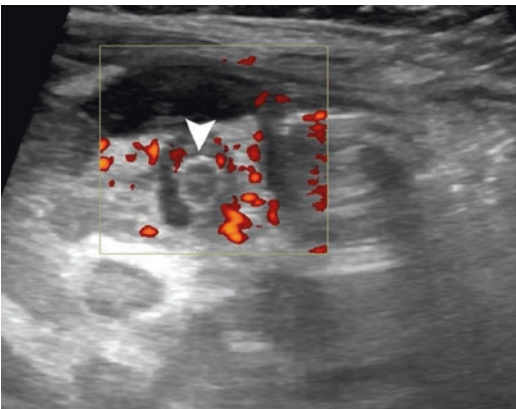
Neonatal appendicitis: Transversal US imaging showing a thickened appendix (*arrowhead*) with hyperemia on color Doppler
